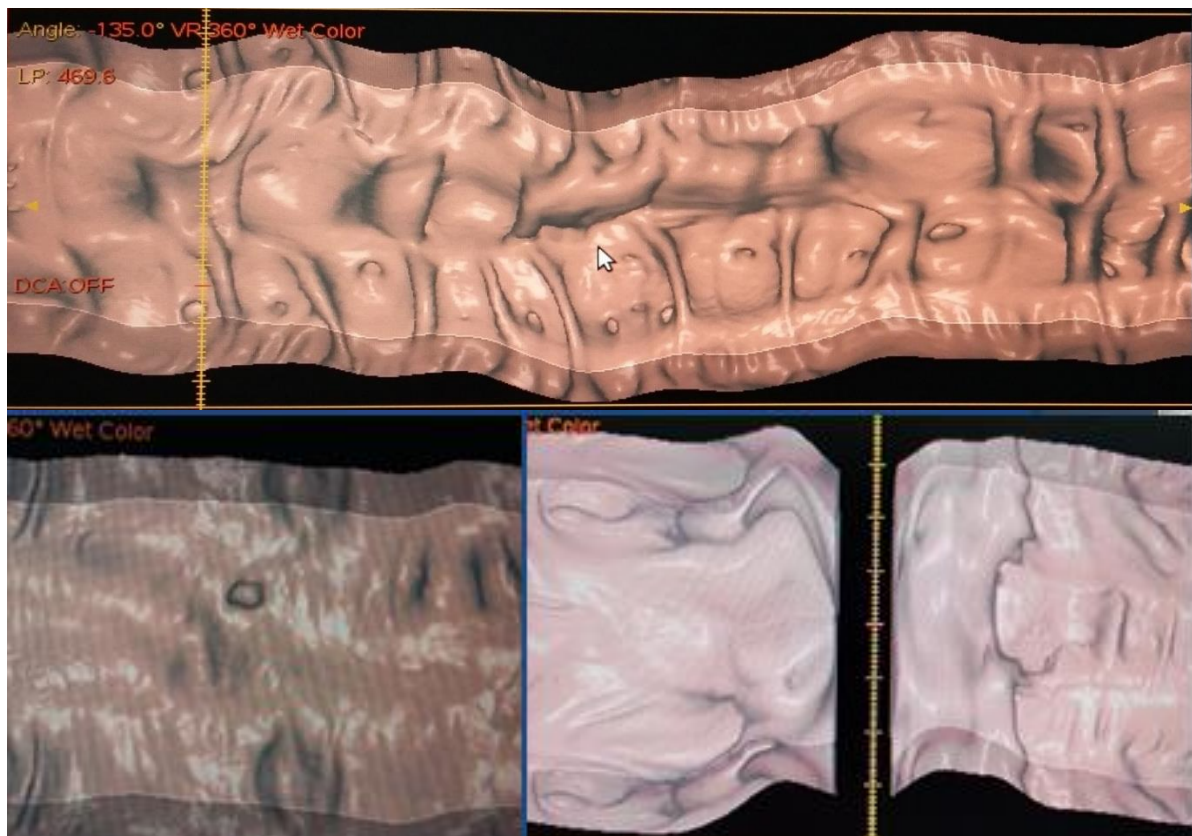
CT Colonography: virtual dissection (diverticulosis, polyp, stenosis-endophytic cancer)
